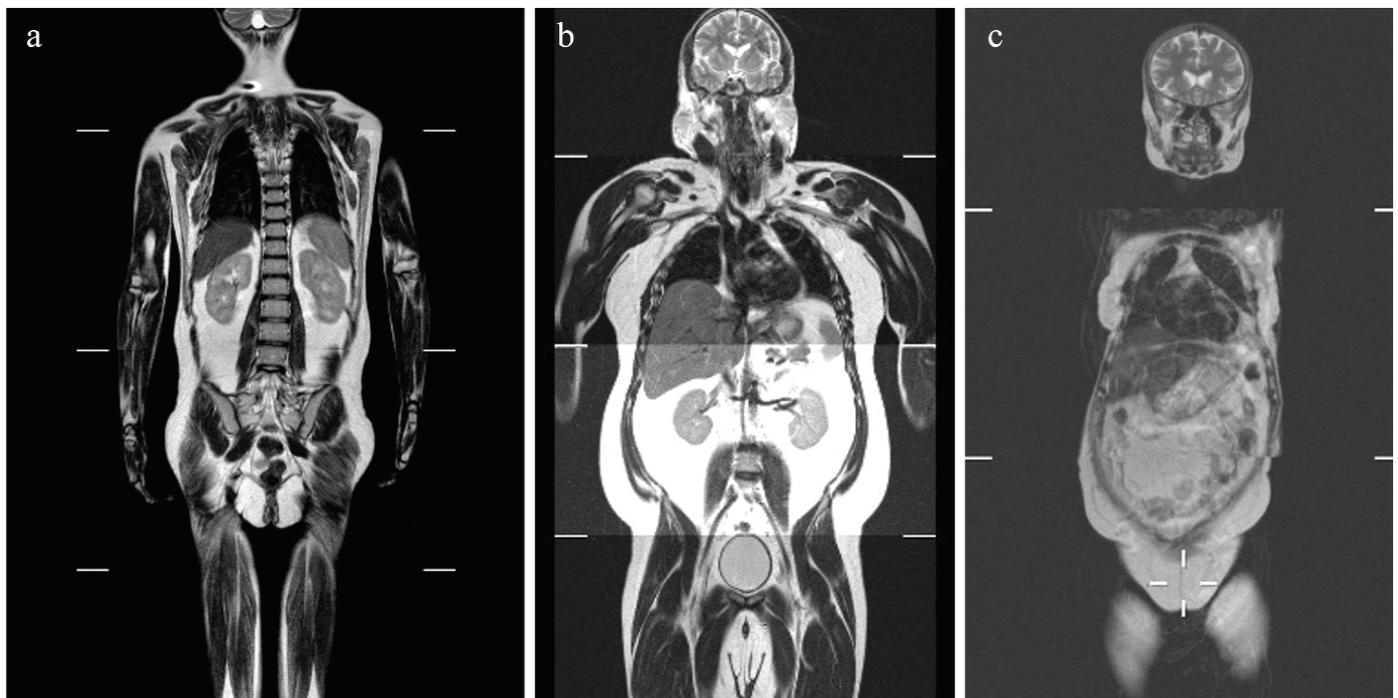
Whole body MRI of the patients. a) Patient 1; regional fat accumulation in the gluteal and abdominal side walls. b) Patient 3; focal fat accumulation in the submandibular region, chest, and abdominal side walls. c) Patient 4; focal fat accumulation in the bilateral submandibular region and gluteal region
